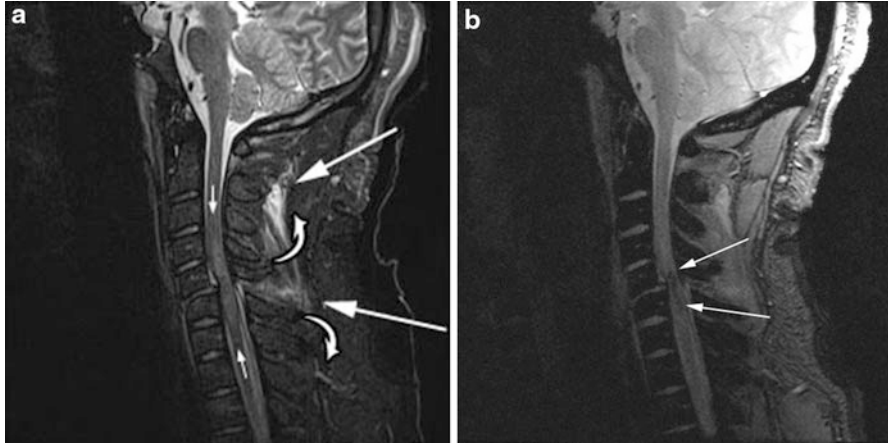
Spinal cord injury. 17-year-old found in a ditch who was thought to have been thrown from a motorcycle. A sagittal T2-weighted MR image through the cervical spine in which signal from fat has been suppressed (a) shows grade 1 traumatic anterolisthesis of C5 on C6. There is resultant spinal canal narrowing at the C5–C6 level with compression of the spinal cord. There is a small T2-weighted bright epidural fluid collection posterior to the C5 vertebral body. There is severe acute cord injury, with signal abnormality extending from approximately C3 down to C7 (*small white arrows*). Edema is seen throughout the interspinous ligamentous complex (*large white arrows*), most severe between the widened C5 and C6 spinous processes (*curved arrows*) consistent with ligamentous injury. A sagittal T2*-weighted image (b) shows susceptibility artifact within the cord indicating cord hemorrhage at C5–C6 (*white arrows*)
